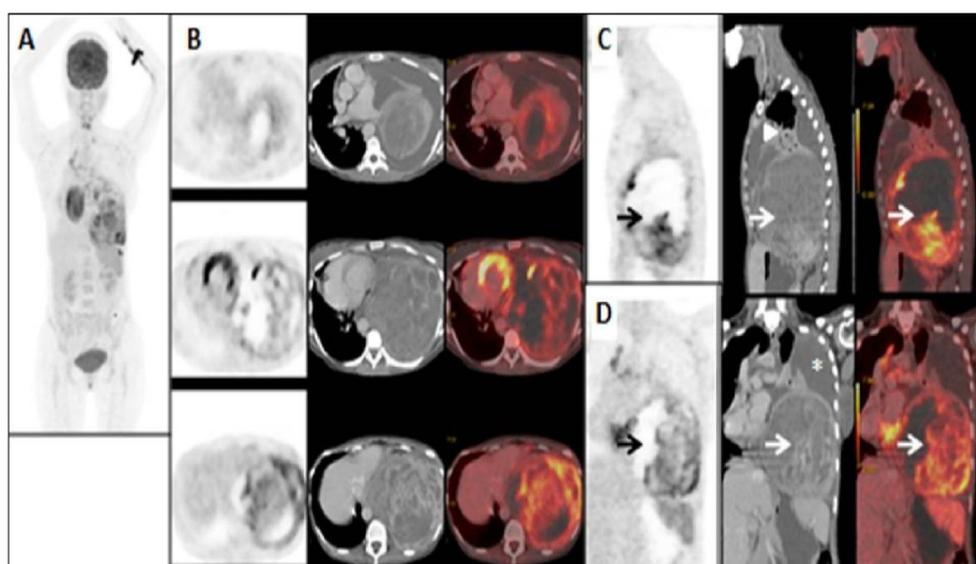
(A)Maximum intensity projection (MIP) PET image (B)Three rows of axial images (PET, CT and fused PET/CT)at different level showing the lesion. The lesion is large in left hemithorax, shifting the mediastinum. It has hypodense and necrotic areas within and shows inhomogeneous FDG uptake (C) Sagittal images (PET, CT and fused PET/CT) showing the lesion. The lesion (marked by arrow) pushes the left lung superiorly with resultant collapse in left lung (arrowhead) (D) Coronal images (PET, CT and fused PET/CT) showing the lesion (marked by arrow). There is reactive pleural effusion seen superior to this lesion (marked by asterisk) and the spleen is seen to be pushed inferiorly by this lesion.
